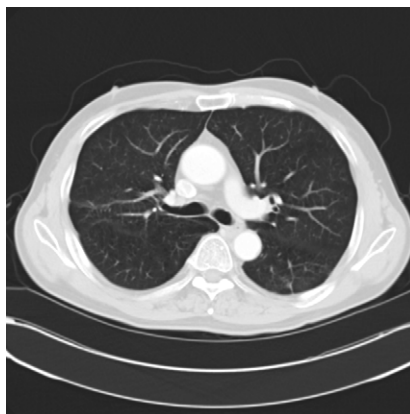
Chest CT showed no evidence of tumor at left hilum at April 2011
